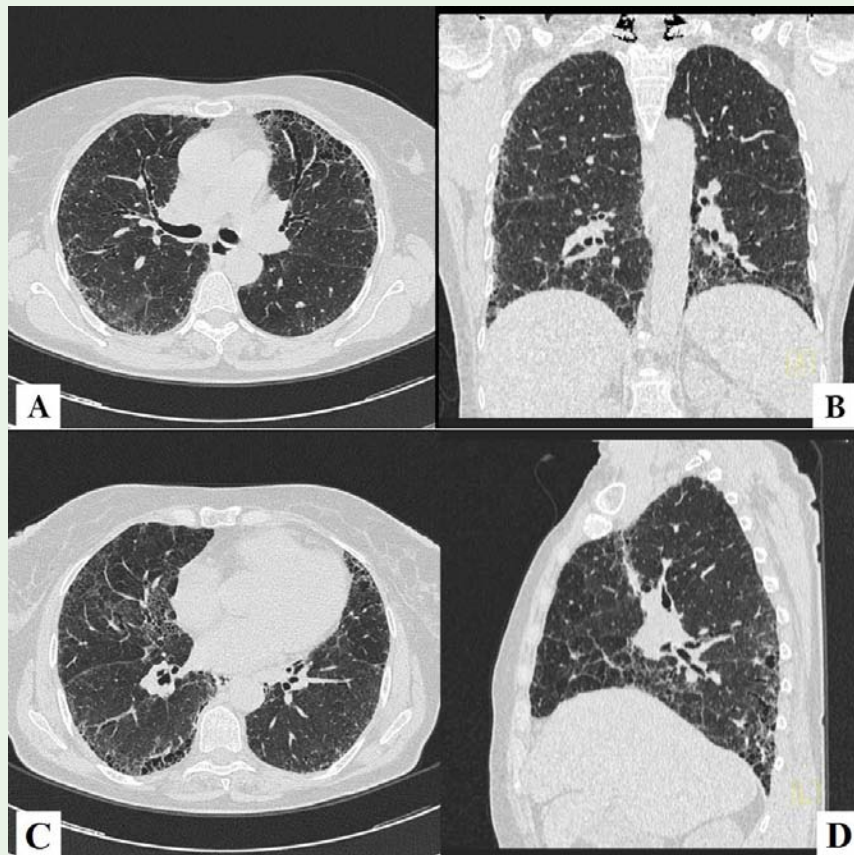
HRCT scans show coarse traction bronchiectasis in the anterior zone of left upper lobe associated with honeycombing (A), with thickening of inter and intralobular septa, especially in subpleural and basal lung areas (B). Honey combing pattern is highlighted with presence of subpleural cysts arranged on one or two files (C,D), predominate in the right apico-posterior lobe and in the lingula (C).
